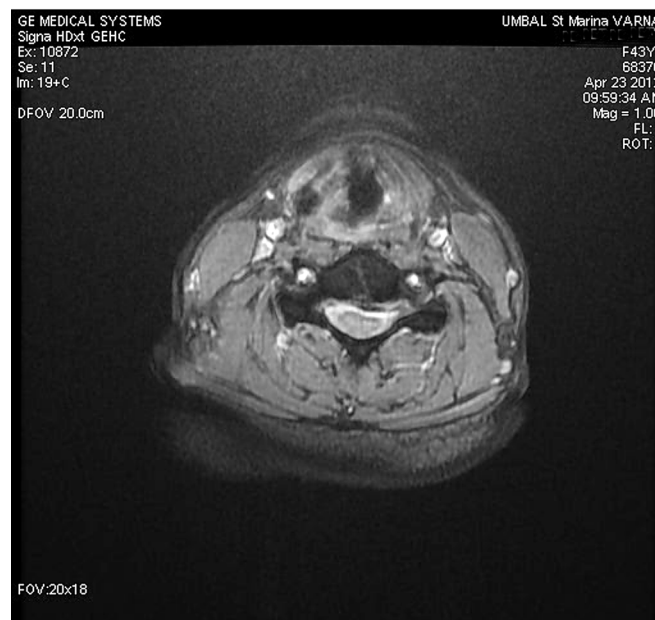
T2-weighted MRI image shows on C5-C6 levels paramedian to lateral disc protrusion on a wide base, with compression on the left nerve root. There are lesions in the spinal cord centrally located, also. These are T2 series in axial projection.
